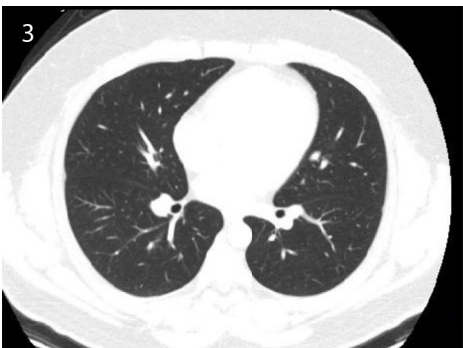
Follow-up (after 87 days) dual-energy computed tomography (DECT) images of the same patient as in Figures 1 and 2. Follow-up DECT scan reveals no parenchymal (Figure 3) or perfusion (Figure 4) abnormality.
